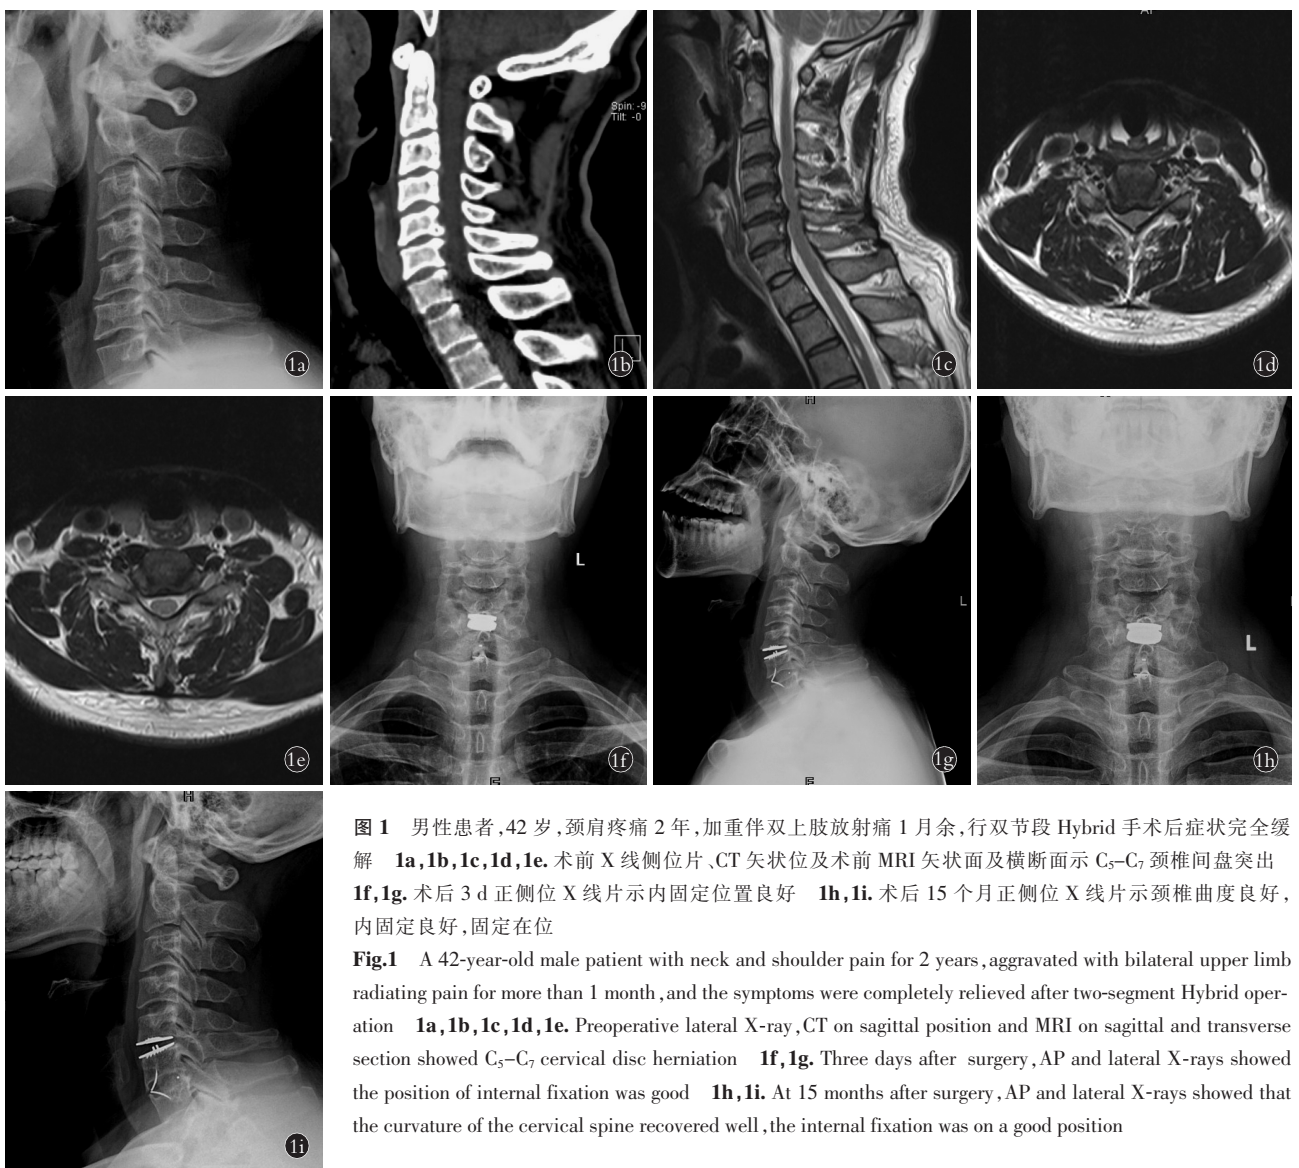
男性患者, 42 岁, 颈肩疼痛 2 年, 加重伴双上肢放射痛 1 月余, 行双节段 Hybrid 手术后症状完全缓解 1a, 1b, 1c, 1d, 1e. 术前 X 线侧位片、CT 矢状位及术前 MRI 矢状面及横断面示 C<sub>5</sub>-C<sub>7</sub> 颈椎间盘突出 1f, 1g. 术后 3 d 正侧位 X 线片示内固定位置良好 1h, 1i. 术后 15 个月正侧位 X 线片示颈椎曲度良好, 内固定良好, 固定在位
